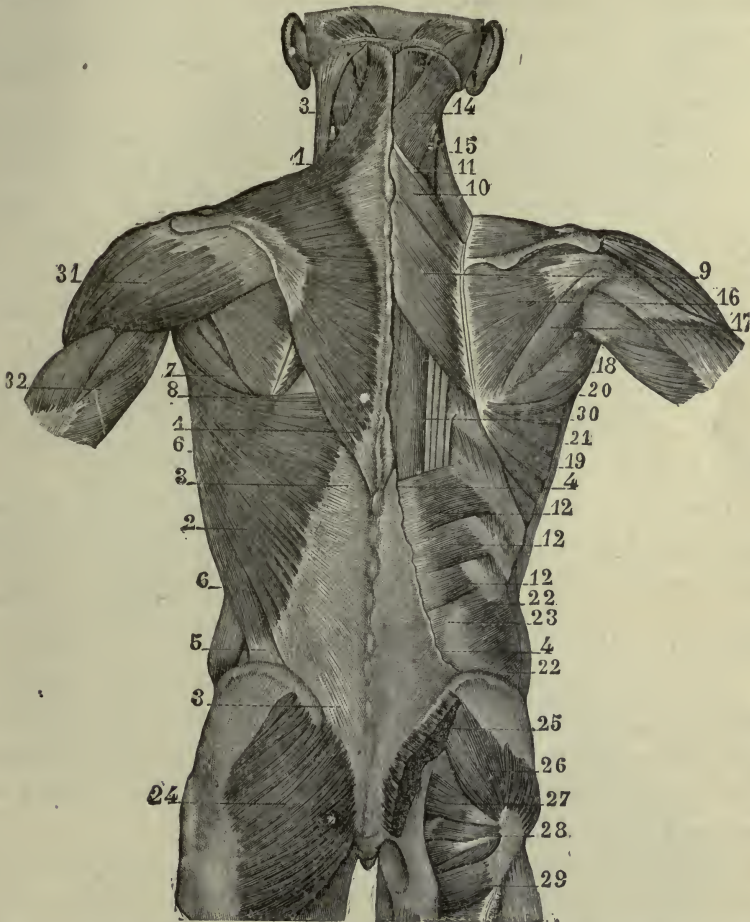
SUPERFICIAL AND MIDDLE MUSCULAR LAYERS OF THE POSTERIOR ASPECT OF THE TRUNK.—Holden.)
